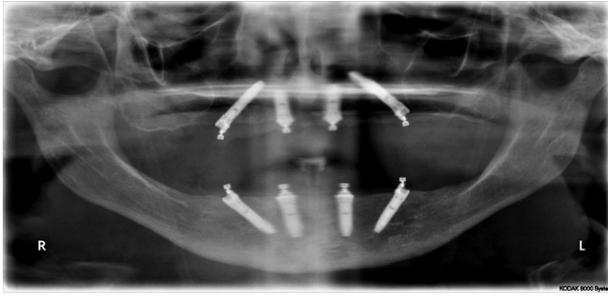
Radiographic control after maxillary full-arch rehabilitation through the “All-on-4” concept (Nobel Biocare AB).
